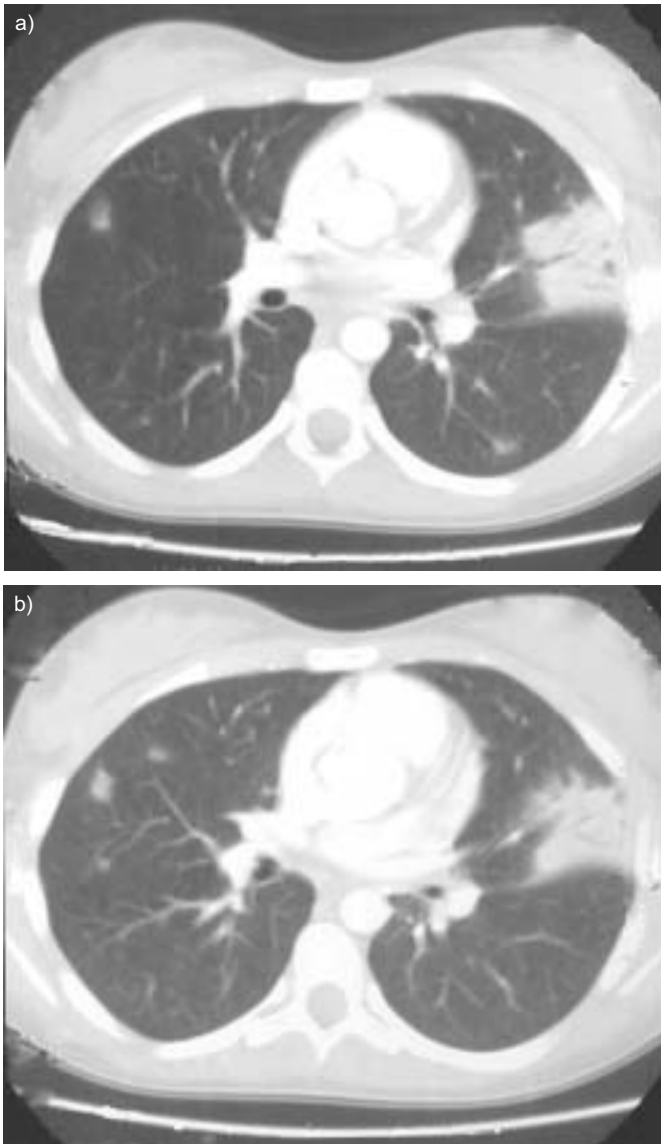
Two windows of the same chest computed tomography scan obtained on October 31, 2003 (day 21 from onset).
